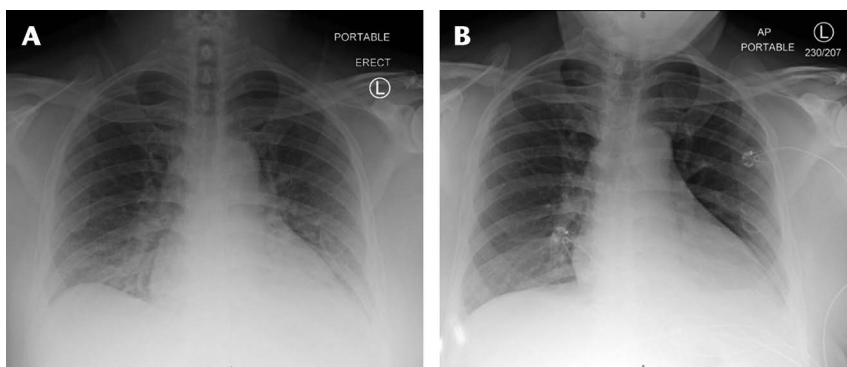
A, Initial chest x-ray on admission. Low lung volumes with subsequent prominence of the cardiomeastinal silhouette and interstitial lung markings. Hazy airspace opacities in the lower lungs bilaterally may reflect atelectasis, although findings are concerning for early developing atypical pneumonia/pneumonitis. No pleural effusion or pneumothorax. B, Follow-up chest x-ray after 3 days, with decreased ill-defined hazy bibasilar opacities, which may represent decreased atelectasis, pneumonia, or combination of both. No large pleural effusion or pneumothorax. Stable borderline enlarged cardiac silhouette. Mediastinal contour within normal limits.
